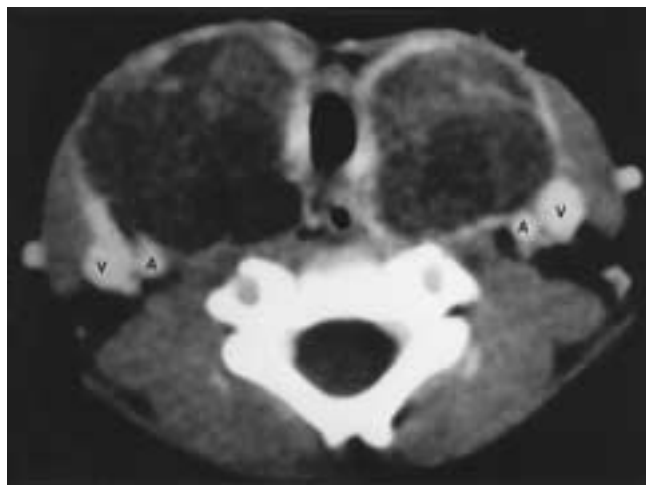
One-year-old child with congenital hypothyroidism and stridor. Axial contrast-enhanced CT shows symmetric enlargement of the thyroid gland. Note that the gland does not enhance normally. The common carotid arteries (A) and internal jugular veins (V) are deviated posterolaterally, and the trachea is compressed.
